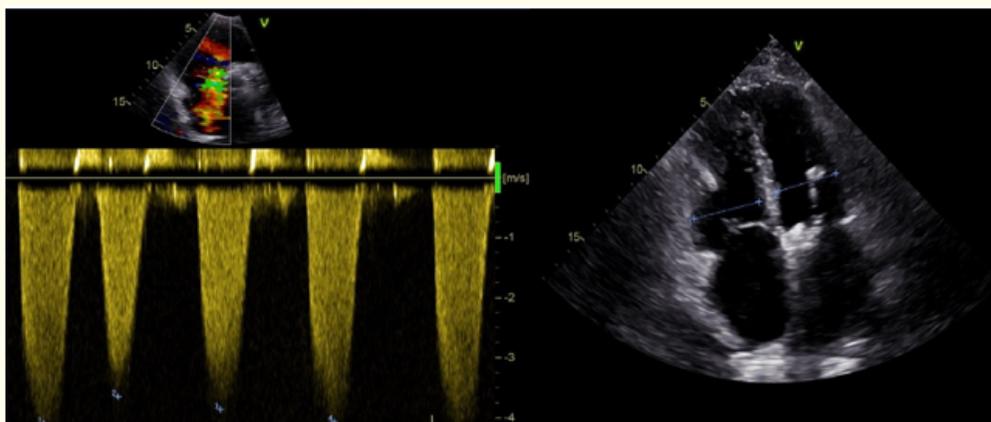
Left, tricuspid regurgitation with V_{max} 4.1 m/s. Right, echocardiography displaying dilatation of the right ventricle and atrium.
